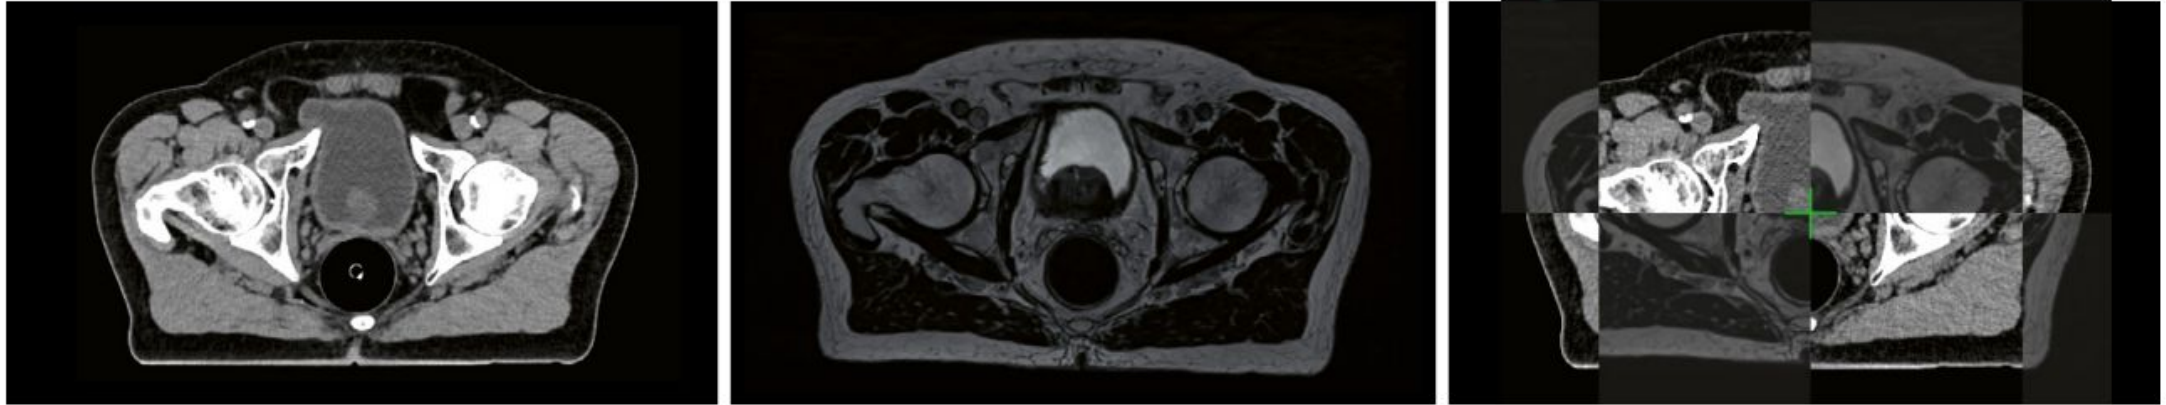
Left image: Planning CT, center image: T2w MRI, right image: registration visualized with the checkerboard tool¹.
